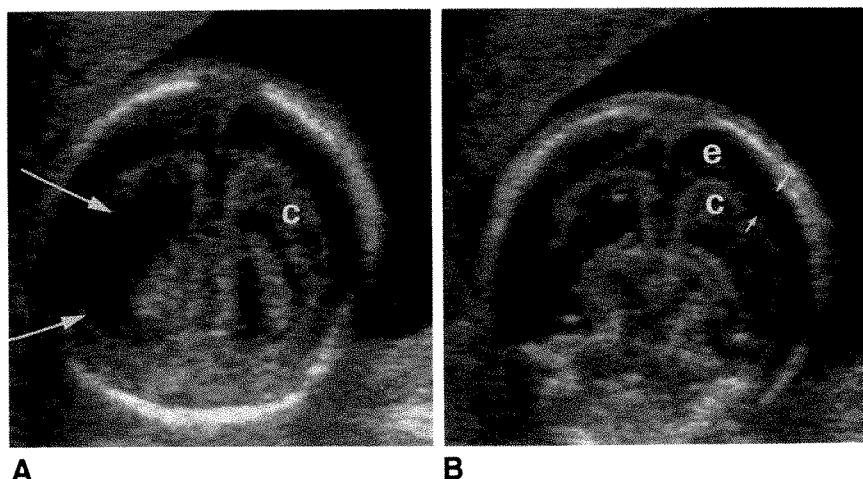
A and B, Twin embolization syndrome. Increased echoes in cerebral cortex (c) are noted on sonograms of surviving twin of this monozygotic pregnancy. Ventriculomegaly (long arrows) and marked atrophy are evidenced by enlarged extraaxial space (short arrows, e).
